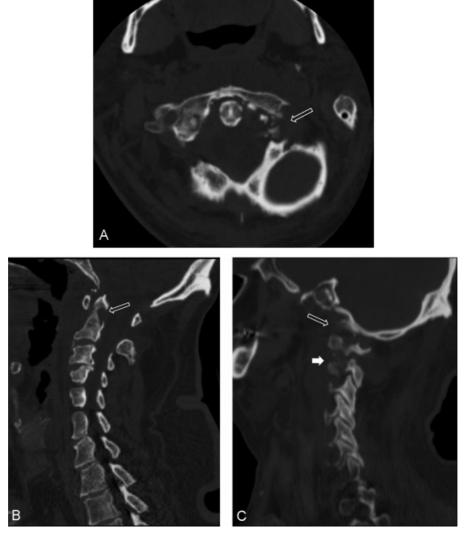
(A) Axial computed tomography ()CT image of C1–C2 demonstrating left C1 lateral mass erosion (arrow). (B) Sagittal CT demonstrating erosion of the odontoid (arrow). (C) Sagittal CT demonstrating left occipitocervical (open arrow) and atlantoaxial articular destruction (closed arrow).
